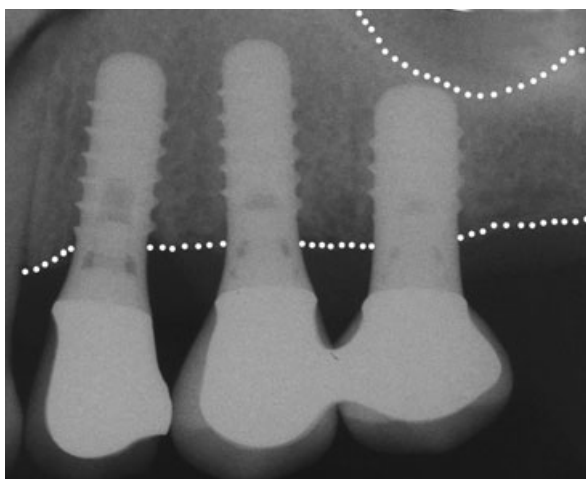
Radiograph of a short (8 mm) implant in the posterior maxilla (the dotted lines represent the outlines of the residual bone).
